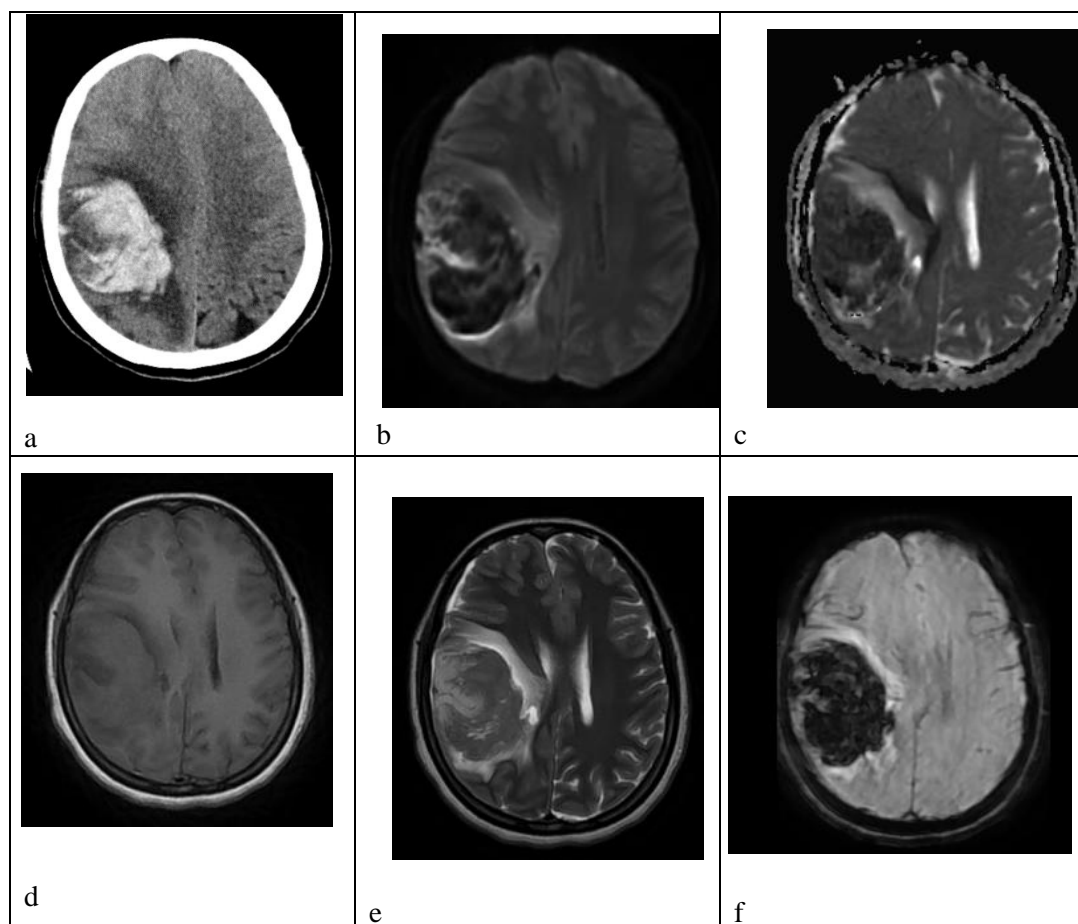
demonstrates *acute* right frontoparietal subcortical & deep hematoma with image (a) points to CT hyperdense appearance (b) marked low signal at DWI with bright rim as well (c) the corresponding low signals at ADC map, (d) T1 with isointense signals (e) T2 image with low signal center and bright rim, finally (f) the SWI images with marked low signals and blooming.
